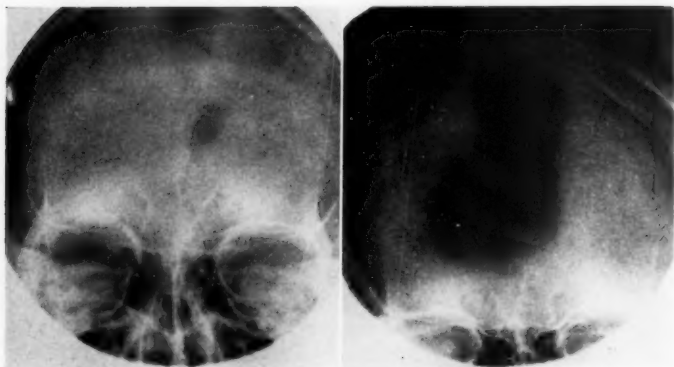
Case 2.—An x-ray showing two areas of osteomyelitis just prior to operation.
